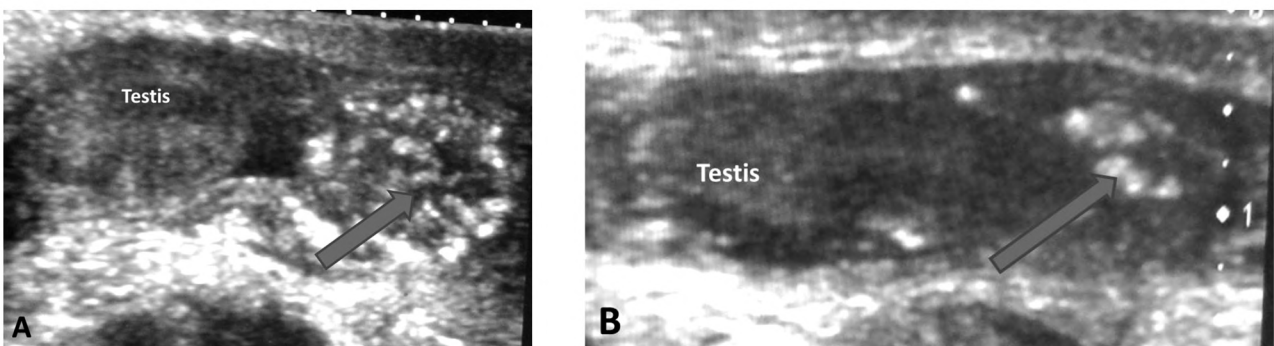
Bilateral meconium peri-orchitis. (A&B) Sonography images demonstrating bilateral partially defined heterogenous lesions at the lower scrotal compartments (meconium components).
